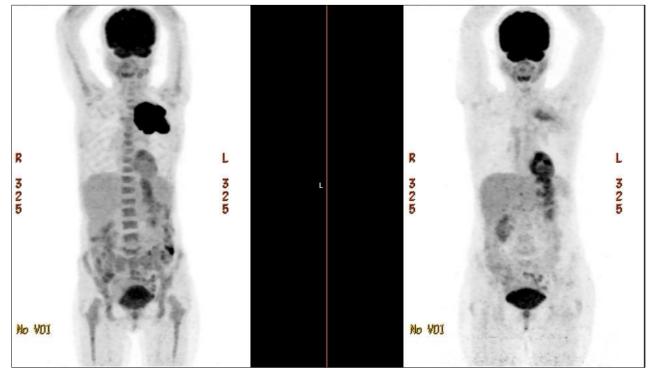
FDG PET/CT scans(the first scan on left and second scan on right with 6 months interval) are showing metabolic response of lung carcinoma and diminished diffuse increased FDG uptake in bones
